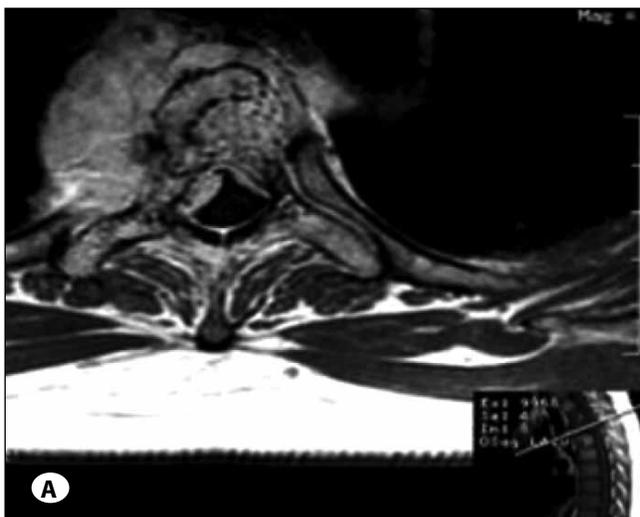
A) MRI showed compression fracture of vertebra of T3, and destruct obviously and an irregular ball-shaped lesion involving the upper thoracic vertebra of T2-T4, which was extended through the neural foramen at T3 to chest cavity. B) Postoperative x-ray showed reconstruction of the anterior column with a titanium cage, and posterior instrumentation.
